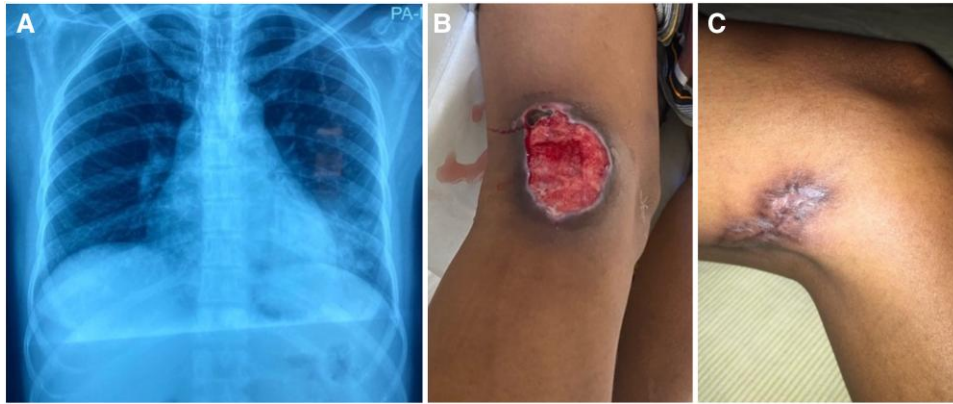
A (left), Chest x-ray demonstrating left lower lobar consolidation. B (middle), Skin and soft tissue infection over the left popliteal fossa. C (right), Healing and scar formation 3 months after commencement of therapy.
